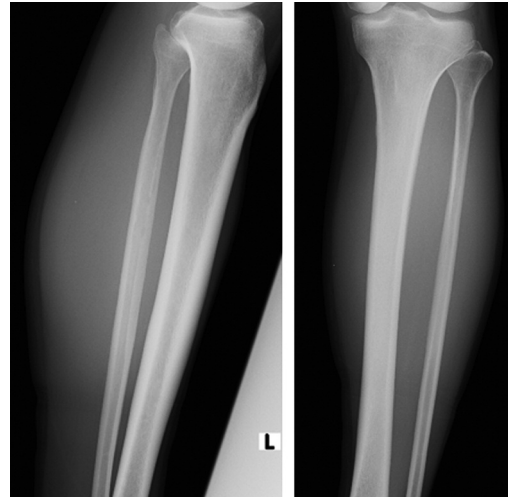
Radiograph of the left lower extremity showed no calcifications or other abnormalities.
